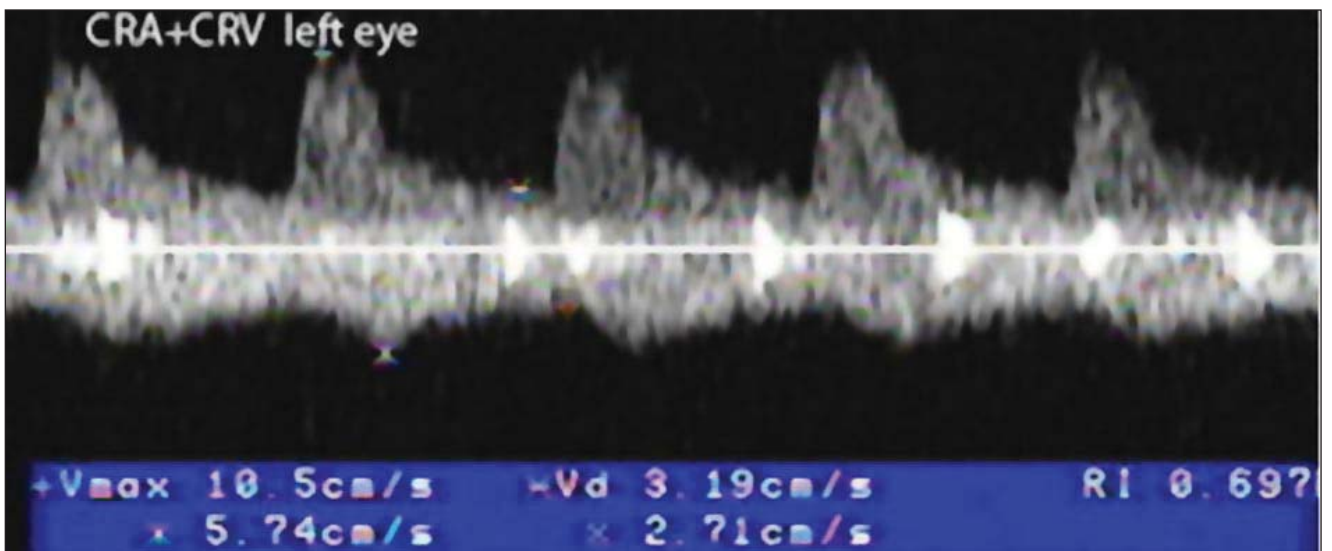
a, b. Patient TL-Spectral Doppler analysis of central retinal arteries (CRA).
